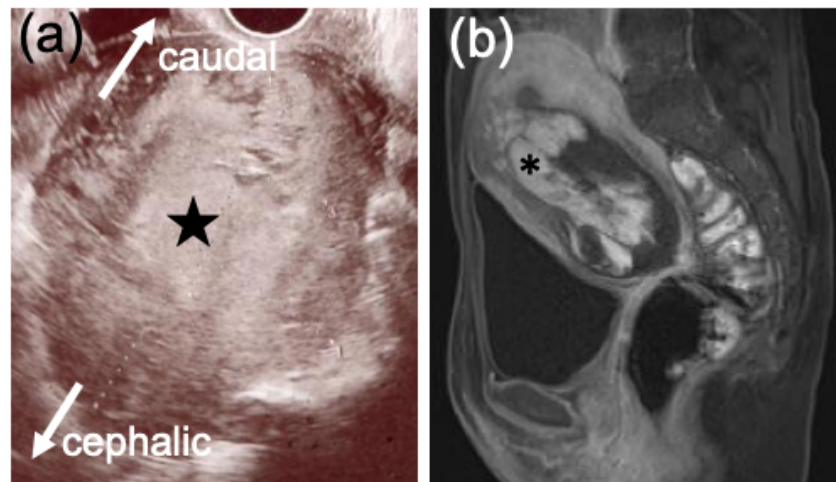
Imaging findings in Case 2. Transvaginal ultrasound shows the residual placenta (high-echoic part: star) in the uterus on postpartum day 8. The placenta is retained in the anterior uterus (asterisk) based on magnetic resonance imaging (T1 gadolinium enhanced) on postpartum day 10.
